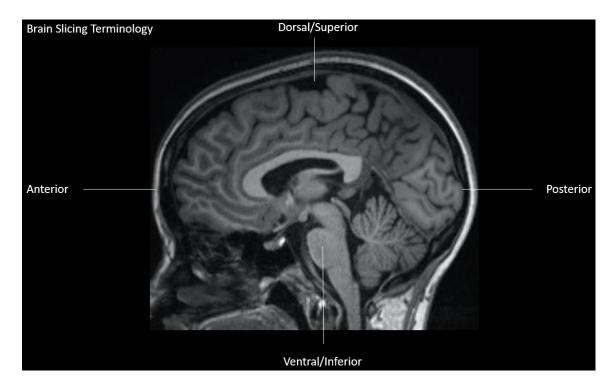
Sagittal View of the Brain Including Directional Terminology. Source: Gateway MRI Center, Joint School of Nanoscience and Nanoengineering, The University of North Carolina at Greensboro.
